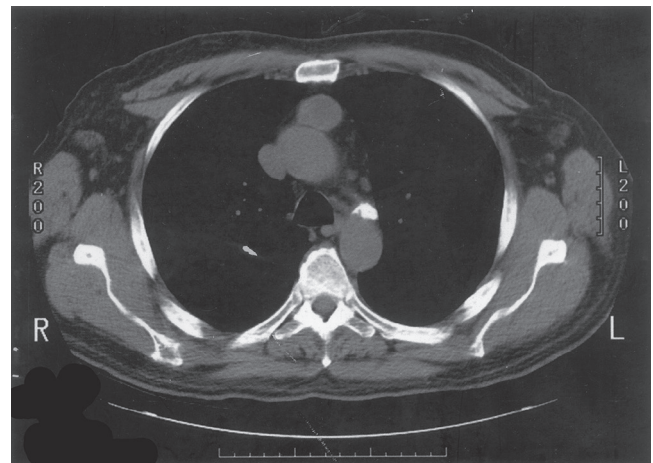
■ Characteristic CT appearance of a noninvasive thymoma: a well-circumscribed, solid anterior mediastinal mass.
